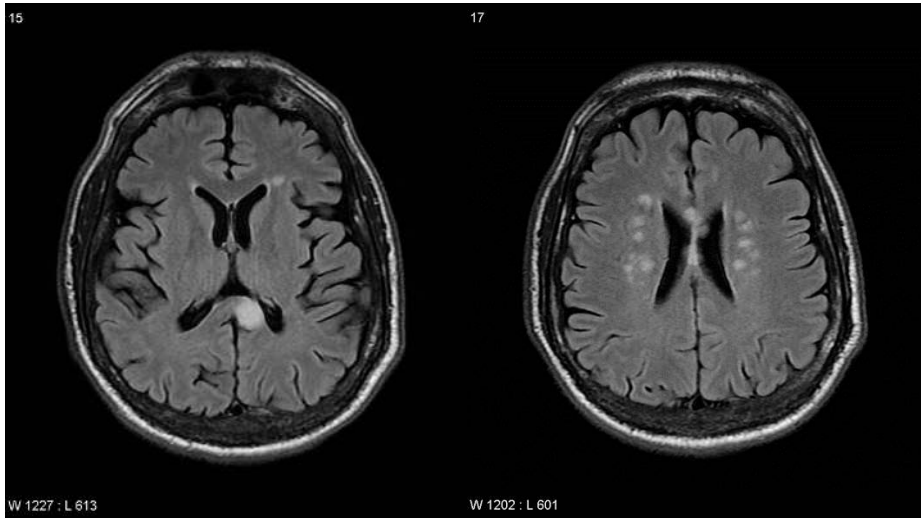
MRI-scan, axial FLAIR show: multiple flair hyperintense lesions in the corpus callosum, the largest in the splenium on the left. Numerous bilateral white matter lesions with central distribution, suggestive for Susac syndrome (different sections)
